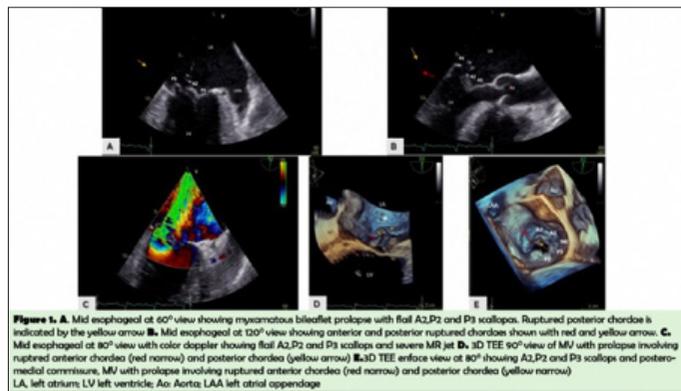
Two and three-dimensional transesophageal echocardiography.
